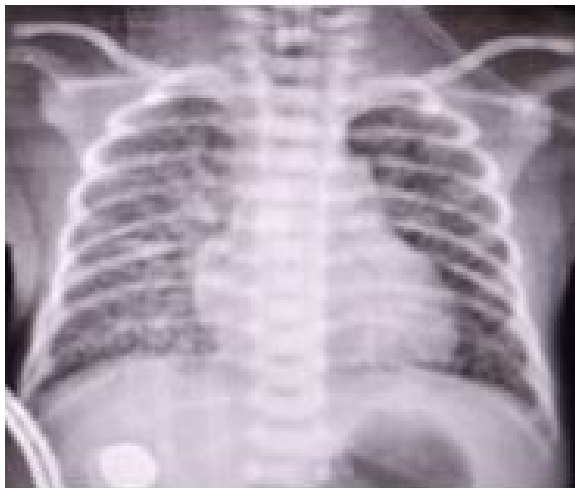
Chest x-ray of the 2nd twin depicting reticulogranular pattern indistinguishable from Hyaline membrane disease
